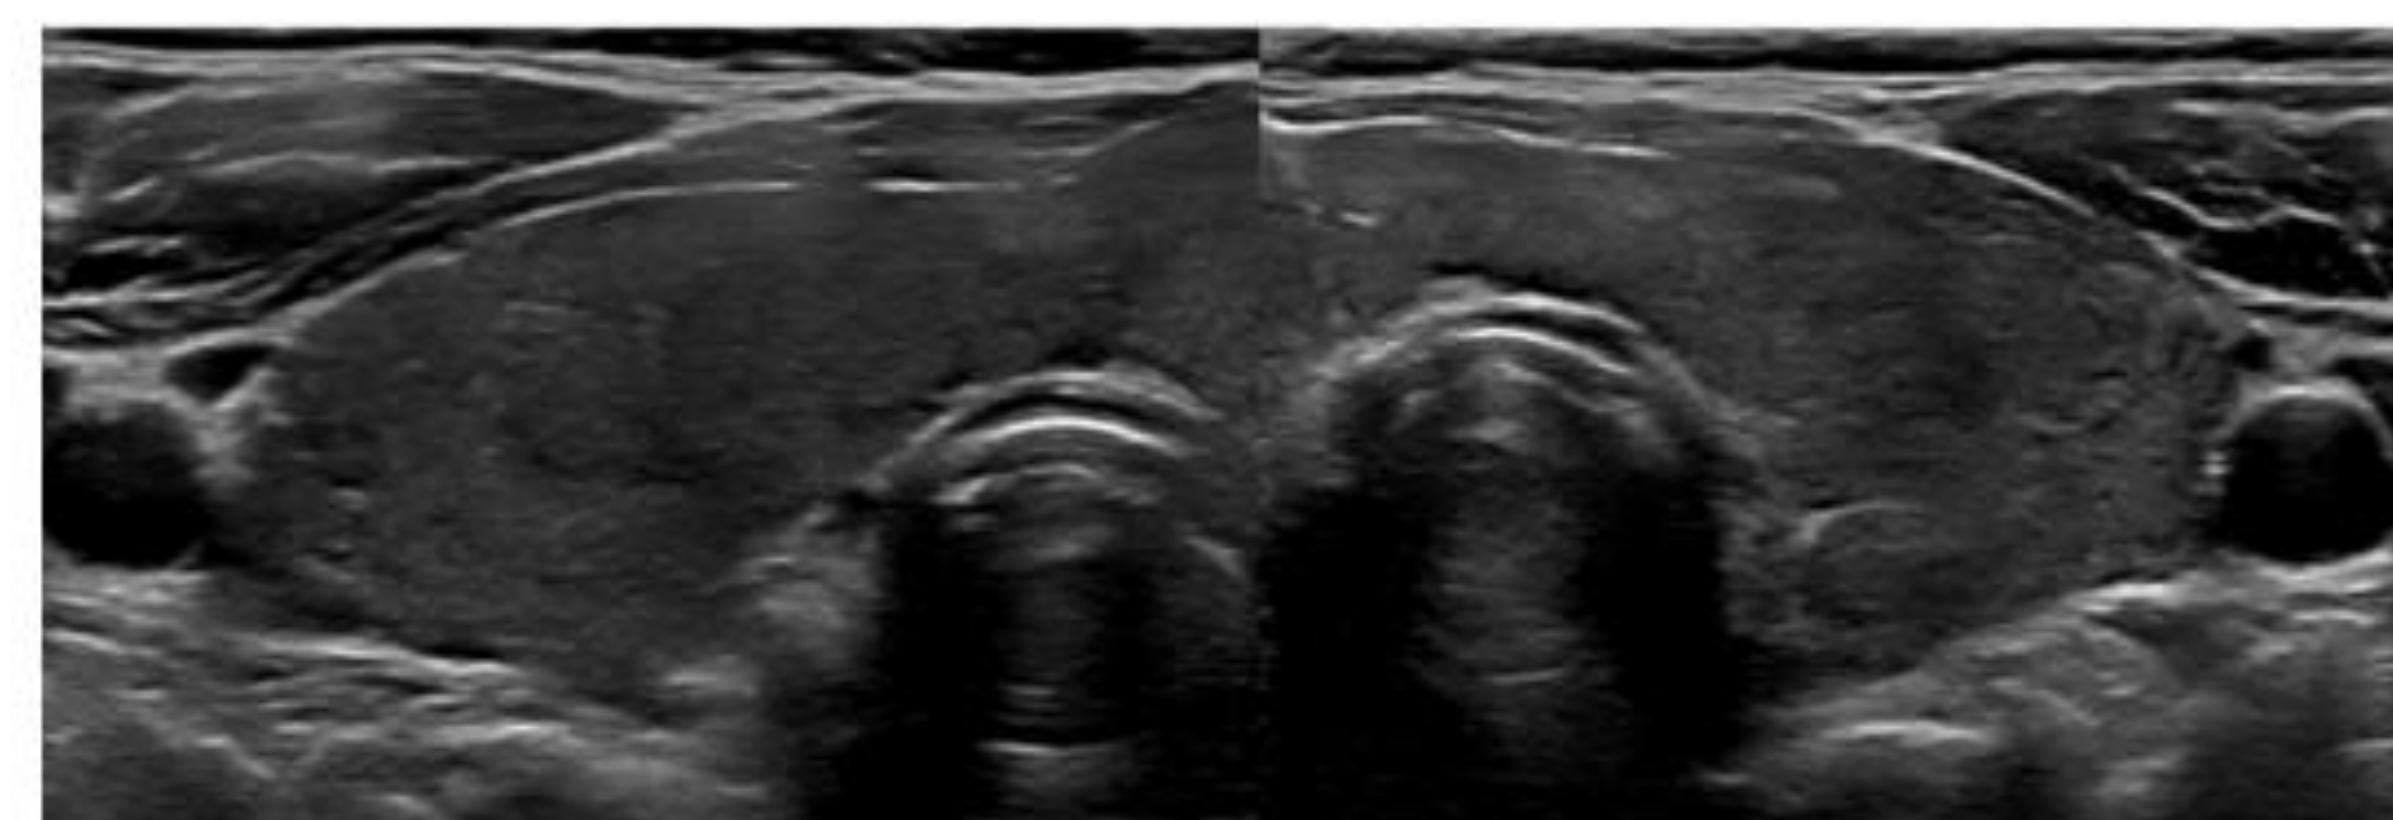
Ultrasound imaging of thyroid gland after 2 doses of Rituxan
